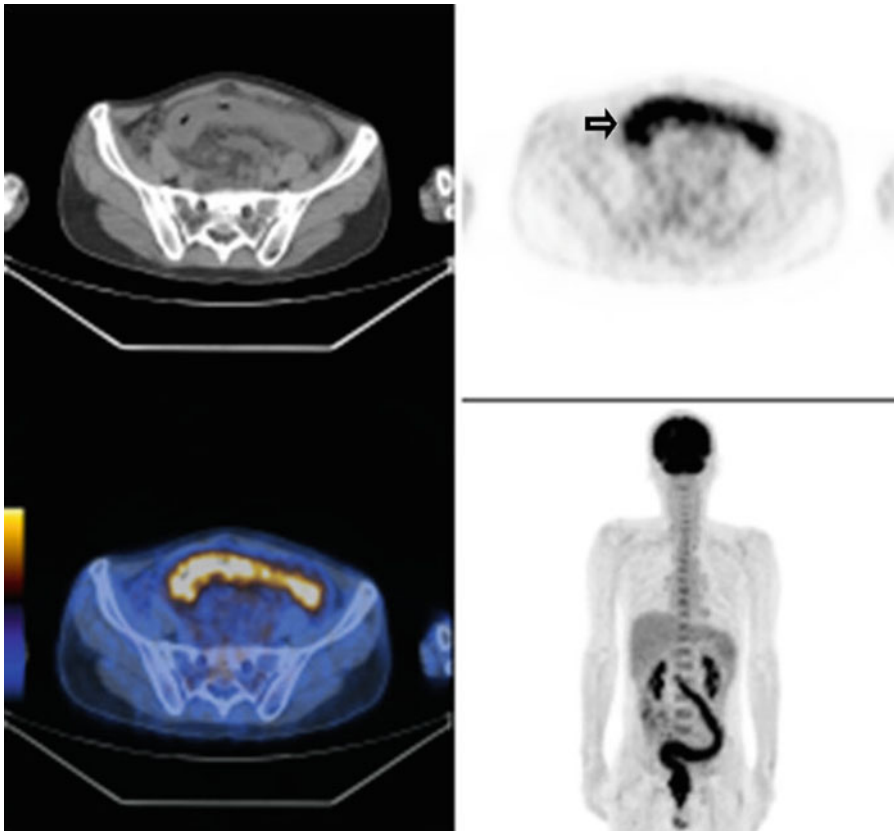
A 57-year-old male who had a history of previous left hemicolectomy for colon cancer was admitted for abdominal pain and diarrhea. FDG PET/CT scan showed
